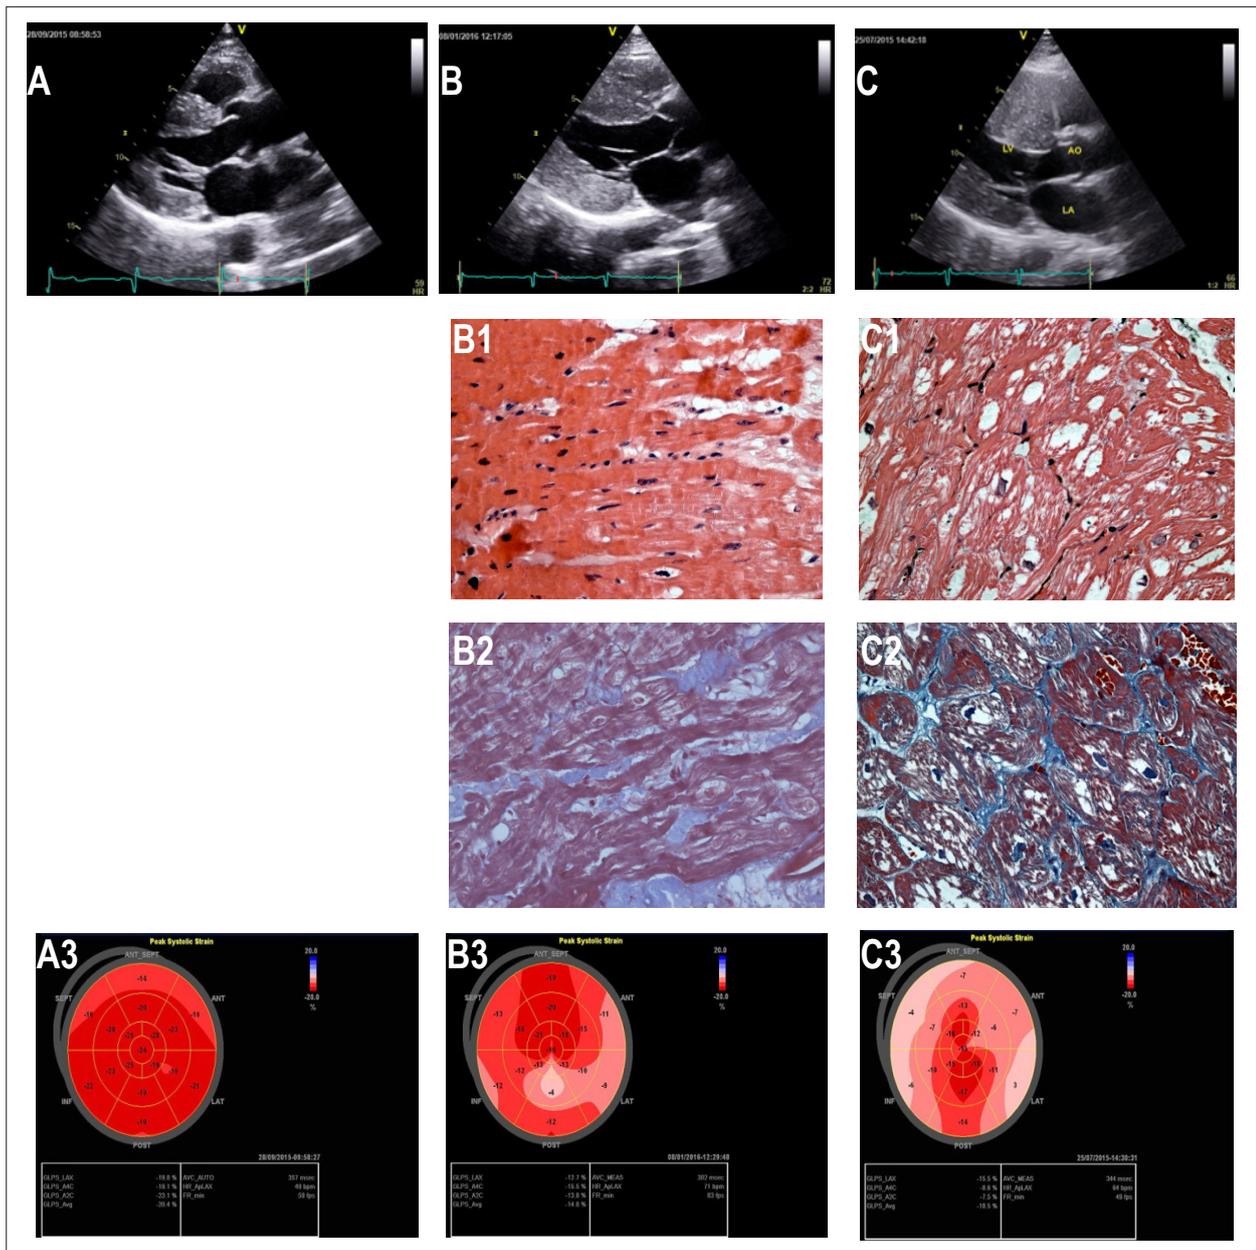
Two-dimensional echocardiography (A, B, C), endomyocardial biopsies (B1, B2, C1, C2) and bullseye maps (A3, B3, C3).
